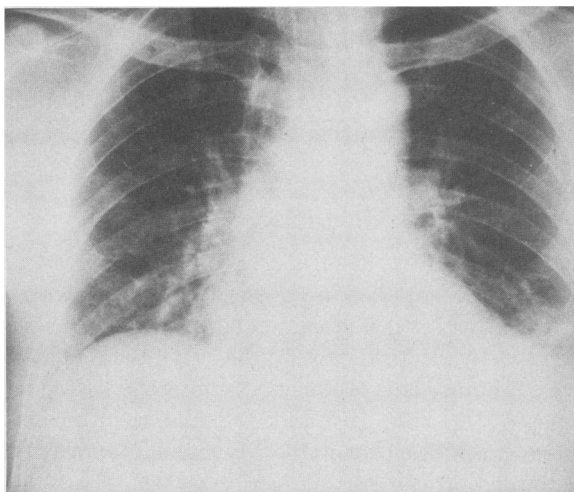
(Case 1) Roentgenogram of the chest showing atelectasis and consolidation of the left lower lobe.
